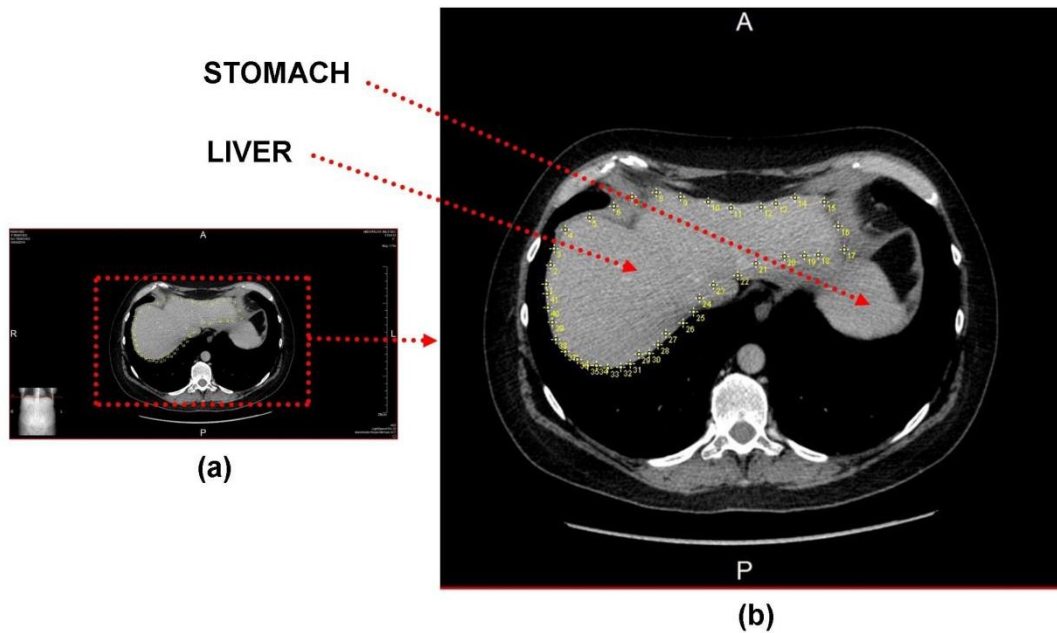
CT scan slice showing 2D coordinates of human liver. (a) Slice number 25, (b) Series of point (yellow in colour) to extract 2D coordinates of liver in the plane of the slice are shown in the enlarged image.
